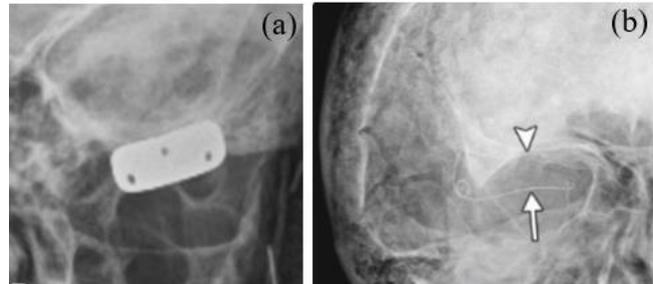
Xray images of (a) Eyelid weight (b) Eyelid wire
